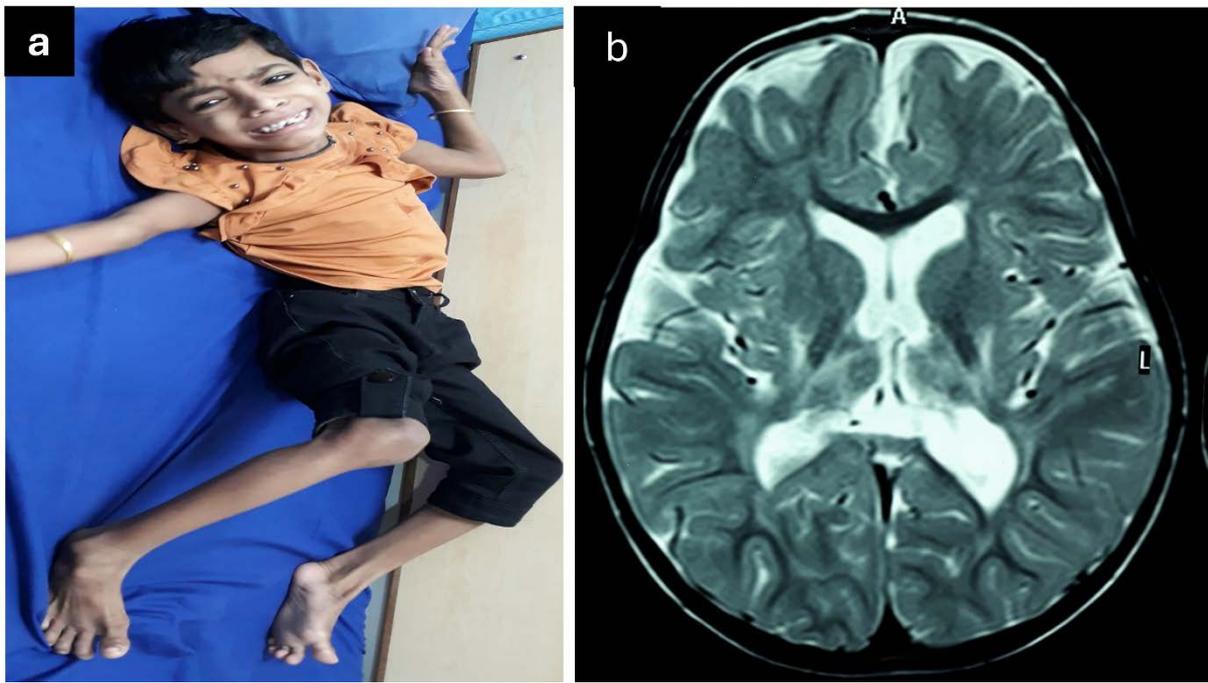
shows clinical and Magnetic Resonance Imaging (MRI) images of a child with dyskinetic cerebral palsy due to hypoxic ischemic encephalopathy. Image 2a shows a clinical photograph of a child with severe generalized dystonia, image 2b shows an MRI of the brain, T2W hyperintensities in the posterior putamen and thalamus.
